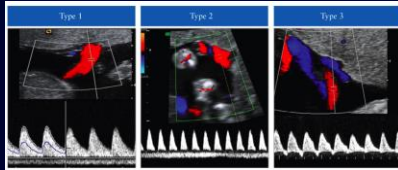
Image from: ISUOG Practice Guideline, Ultrasound Obstet Gynecol 2016;47:247-63.
